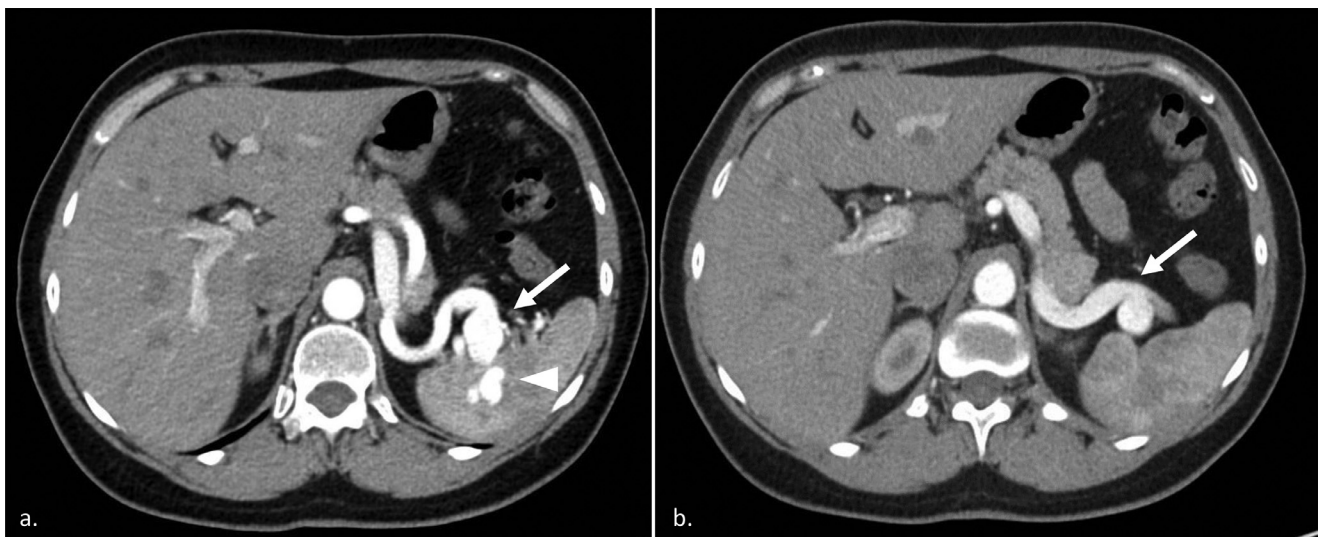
CT of the abdomen in arterial phase demonstrates fusiform arterial aneurysm (arrow) at the splenic hilum with intrasplenic tangle of vessels (arrowhead) (A). Figure (B) demonstrates dilated splenic vein (arrow).
